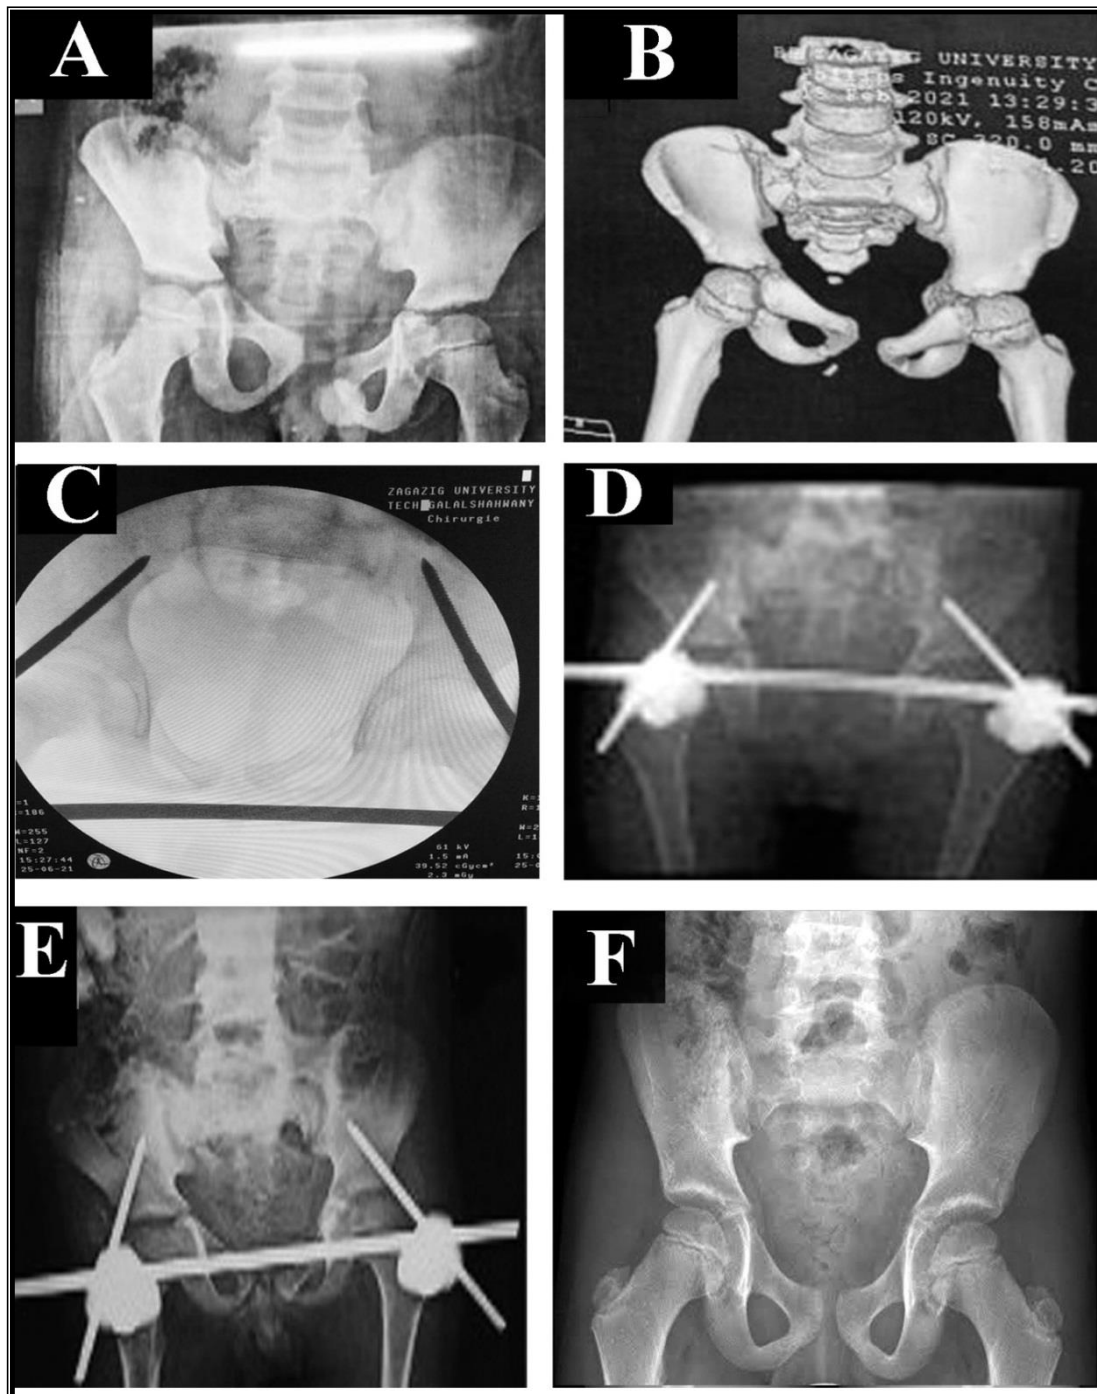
Six years old male patient with Rt. sacroiliac fracture and symphyseal pubis disruption managed by anterior external fixator in an X-frame to achieve posterior stability without need of iliosacral screw in this young patient .A) Preoperative AP x-ray on admission. B) Preoperative 3D reconstruction image. C) Intraoperative flourescopy image. D) Immediate post- operative x-ray. E) Follow up radiograph after 6 weeks. F) Radiograph after 1 year follow up.
